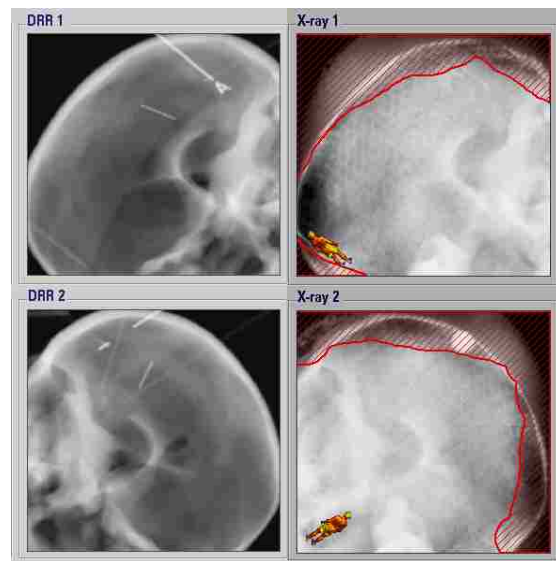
ExacTrac X-Ray Correction Setup. ROIs (shown in red) are contoured leaving the bony orbit area to the used for fusion.
